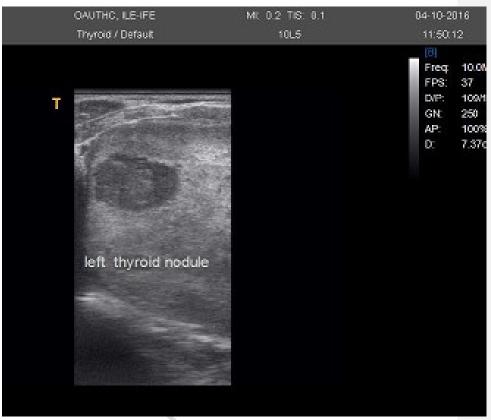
Longitudinal plane B mode ultrasound scan of the thyroid gland showing an oval shaped, smoothly marginated, wider than tall hypoehoic nodule.
